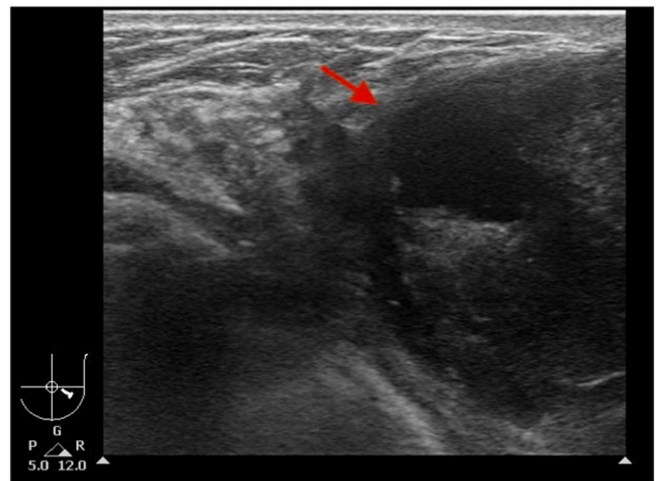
Breast sonography revealing highly suspected malignancy (ACR BI-RADS category 5) (Arrow).
